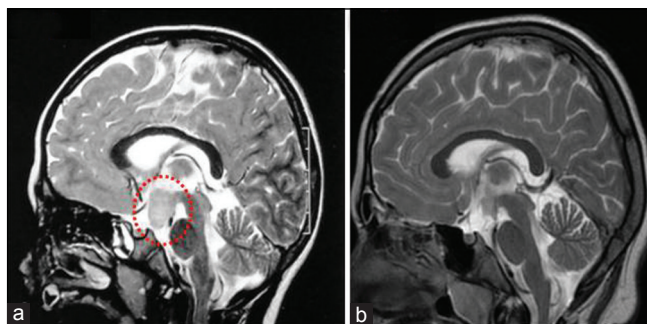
T2-weighted (T2W) sagittal images of a patient showing a pedunculated variety of hypothalamic hamartoma. The preoperative image is shown on the left with the lesion encircled (a). The postoperative image following surgical resection is shown on the right (b)
